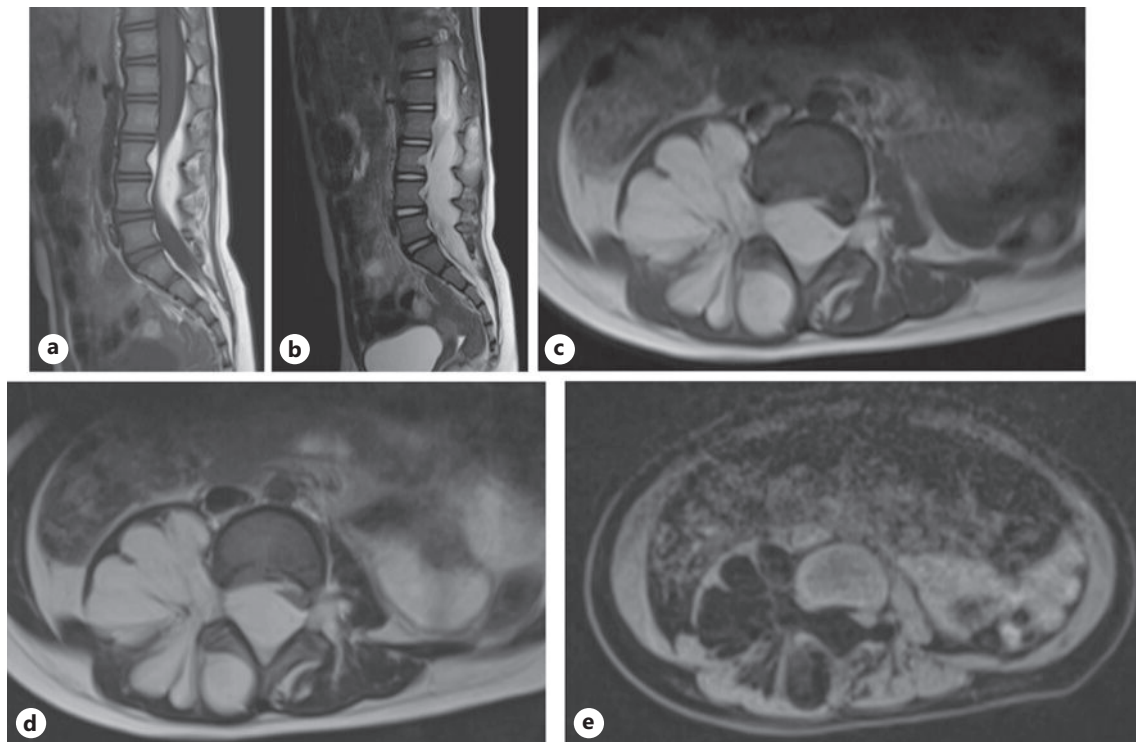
Preoperative magnetic resonance images (MRIs), showing hyperintense tumor (9 × 5 cm) exceeding into the spinal canal from paraspinal muscle on T1-weighted sagittal (a), T2-weighted sagittal (b), T1-weighted axial (c), T2-weighted axial (d), and fat-suppression sequence (e).
